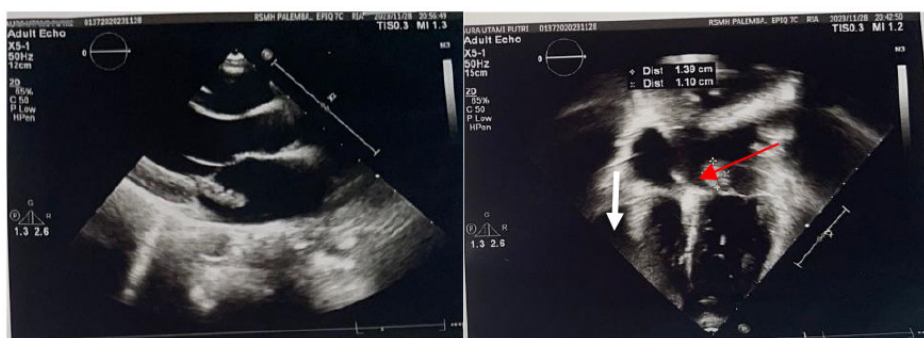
Echocardiography showed vegetation in the anterior mitral valve (red arrow), severe mitral regurgitation, moderate tricuspid regurgitation, and minimal pericardial effusion (white arrow)
